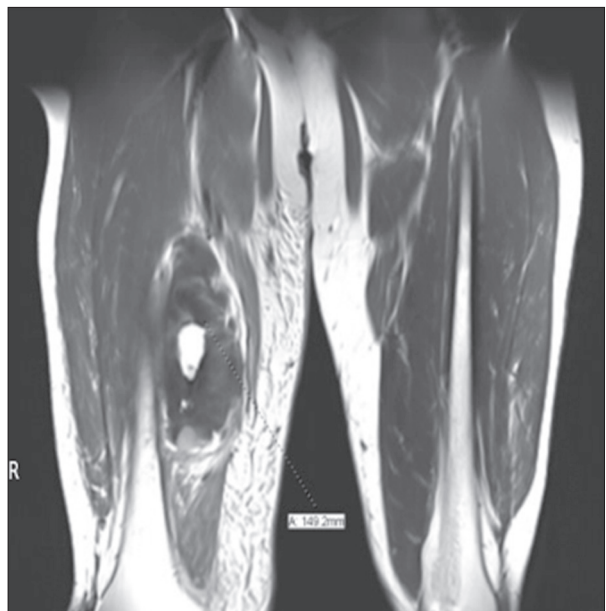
MRI of right thigh: A large mass lesion measuring 18×8×7.5 cm, in the mid-thigh just adjacent to the femoral cortex without obvious bone destruction.
